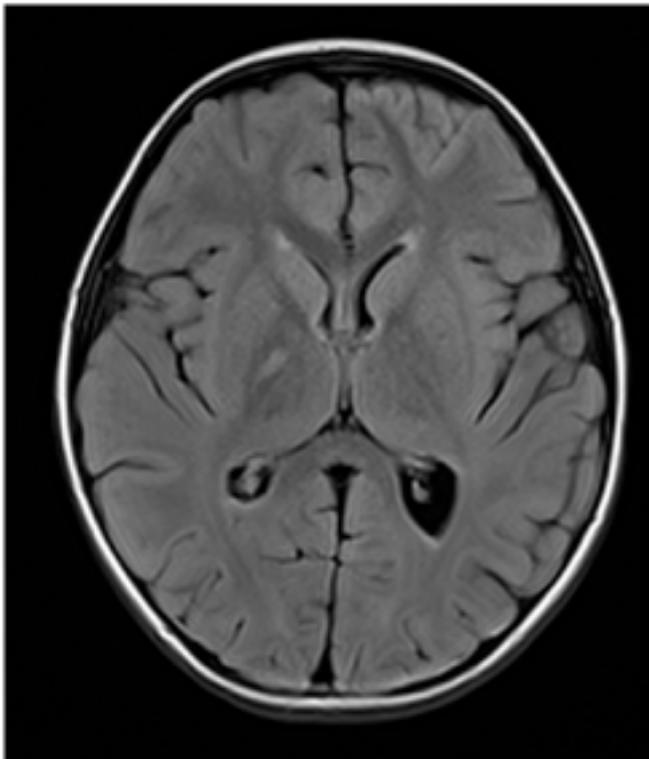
A-D: T2 (A) and FLAIR (B-C) axial MRI of the brain of a 5 year-old-boy (patient 1) obtained nine days after onset of symptoms showing several ischemic lesions : basifrontal bilateral (A-B) and in the posterior arm of the right internal capsule (C). Figure D shows diffusion sequences of the basifrontal lesions.
